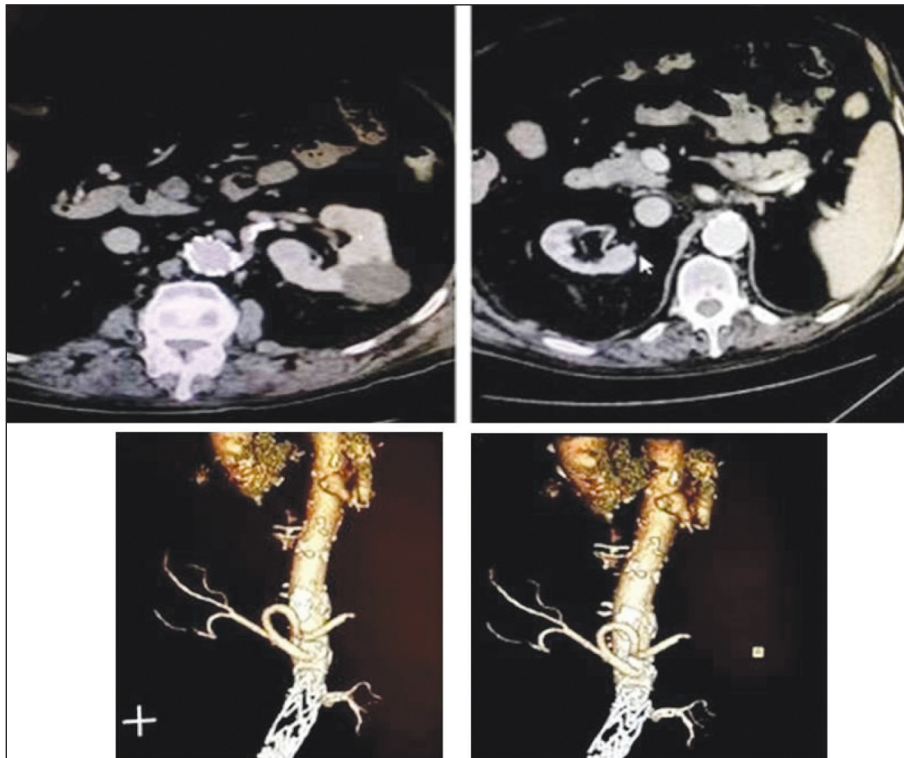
Axial sections evaluated on computed tomography and computerized tomography images viewed in coronal section and in three-dimensional reconstruction. Ateromasia diffuse fibrocalcific aortic and (multiple) renal arteries in a diabetic patient (double left renal artery with aortic origin), with ischemic heart disease and other severe comorbidities. The figure shows a double renal artery on the right, highlighting the emergence of both the right renal arteries of fibrocalcific plaque resulting in reduction of the caliber of the most cranial artery (thickness at the emergence of about 3 mm) and occlusion of the artery lumen more caudal. Also present of fibrocalcific plaques located at the emergence of the left renal artery, but without significant stenosis.
